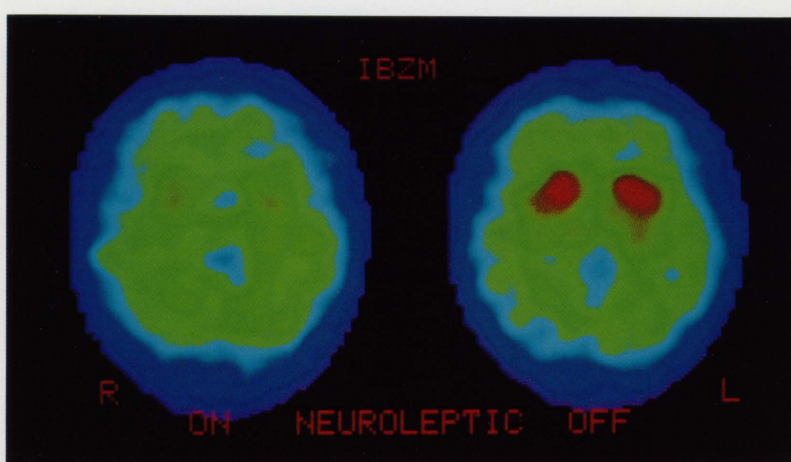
SPECT of a 22 year old male patient with visual hallucination secondary to alcohol abuse on and off neuroleptic therapy. The first scan while the patient is on neuroleptic therapy for 2 weeks shows markedly reduced basal ganglia uptakes bilaterally {basal ganglia/frontal cortex (BG/FC) ratio: 1.30}. The second scan of the same patient 3 weeks after withdrawal from neuroleptics shows marked recovery in the basal ganglia uptakes (BG/FC ratio: 1.61).
